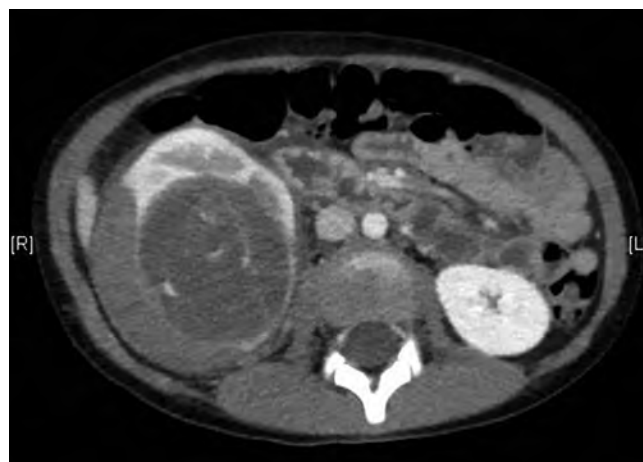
Computed tomography scan of a Wilms tumor that demonstrates preoperative rupture with perirenal hemorrhage.
